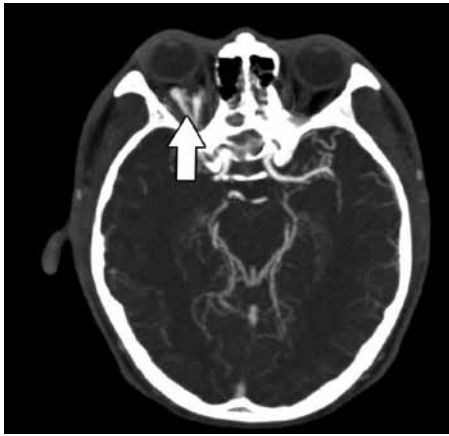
Computed tomographic angiography scan showing vascular lesion in the retrobulbar fat without hemorrhage consistent with an orbital arteriovenous malformation (arrow).
